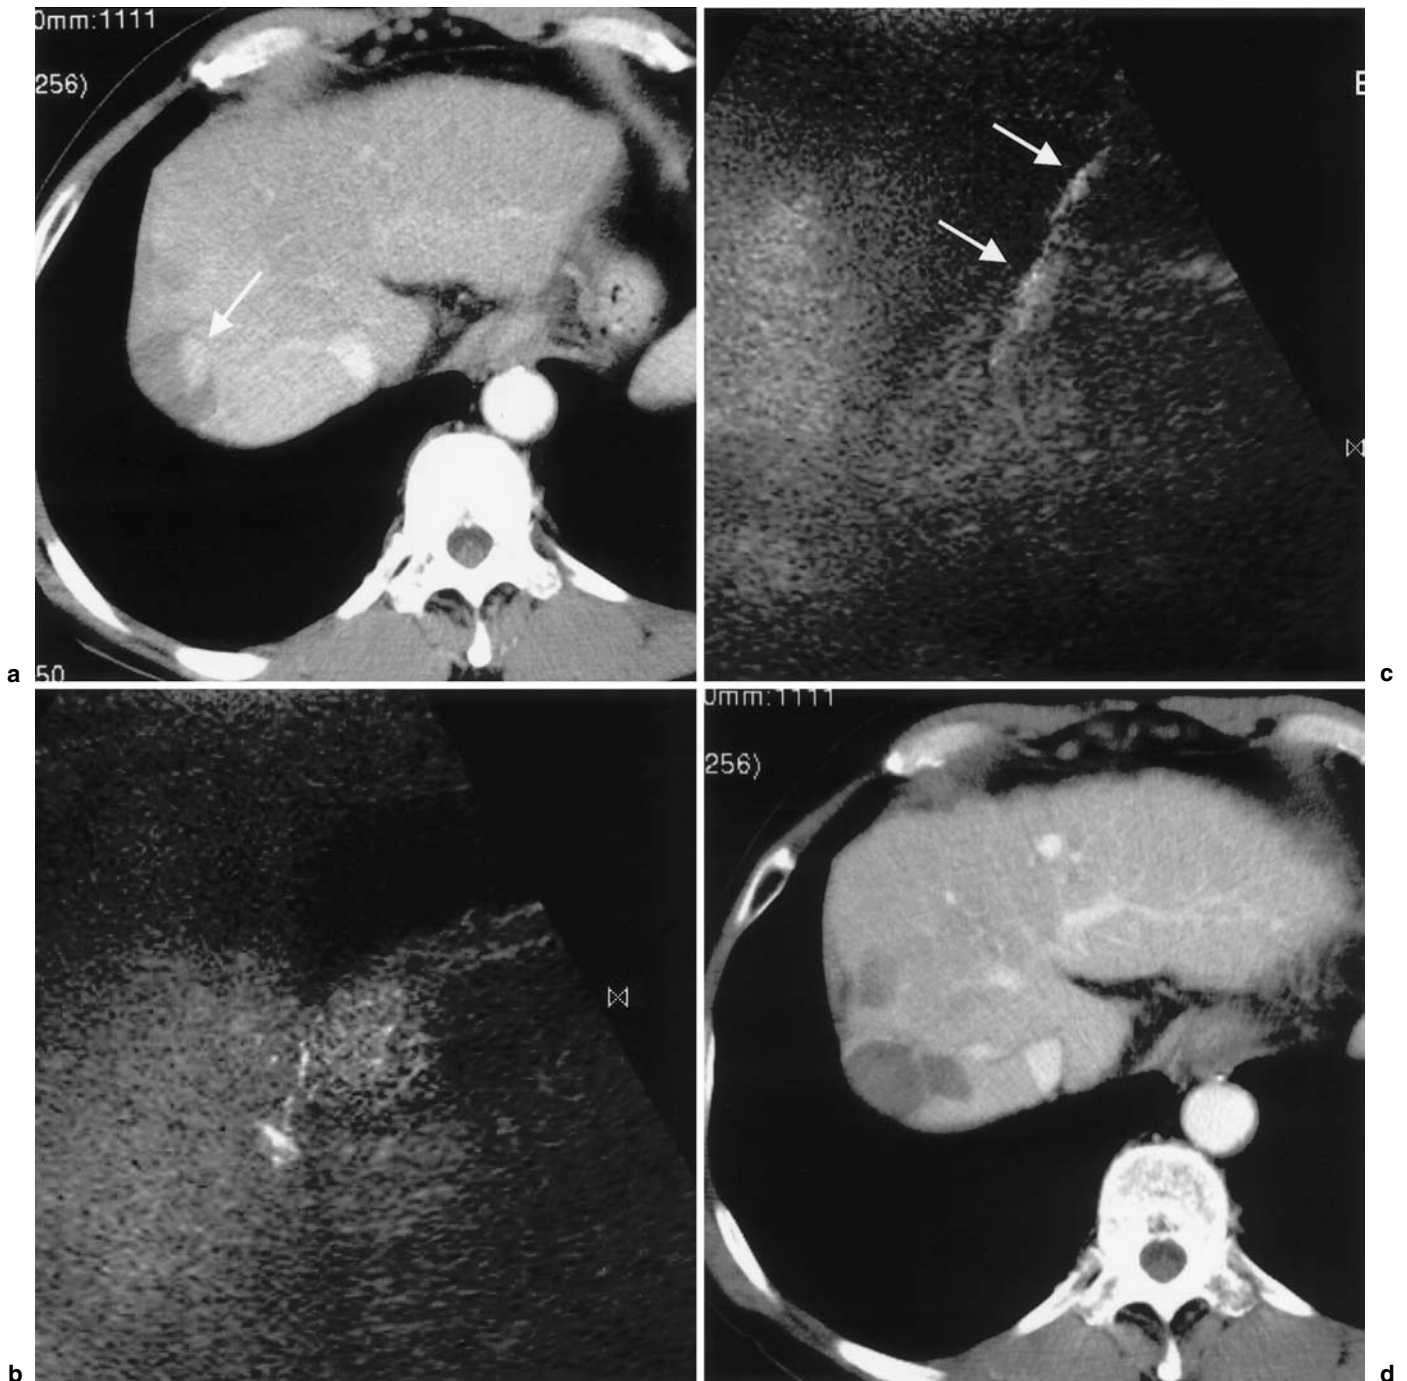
A 1.0-cm recurrent hepatocellular carcinoma after local therapy in the right hepatic dome of a 65-year-old man. a Early-phase dynamic CT scan shows a recurring tumor (*arrow*) in the right hepatic dome. The surrounding area, which was previously treated by radiofrequency ablation, is not enhanced. b After the intrathoracic injection of 5% glucose solution, contrast harmonic US shows the enhancement of viable foci of hepatocellular carcinoma (*arrow*). c Contrast harmonic US shows a radiofrequency electrode needle inserted into the viable foci of hepatocellular carcinoma (*arrows*). d Early-phase dynamic CT scan obtained 6 months after radiofrequency ablation therapy shows that the tumor and the surrounding area are not enhanced, indicating complete necrosis of the lesion
